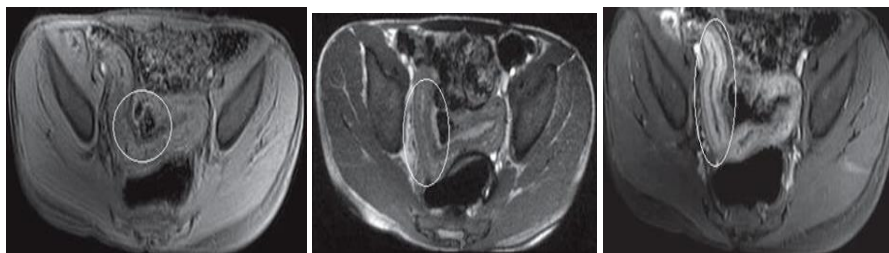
Axial T1 Weighted MR image shows thickened wall of ileum in Crohn's disease.
